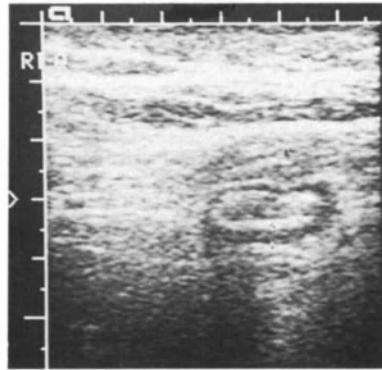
Ultrasound demonstration of acute appendicitis. Cross-section of a fixed dilated appendix with thick wall (measuring cursors).
